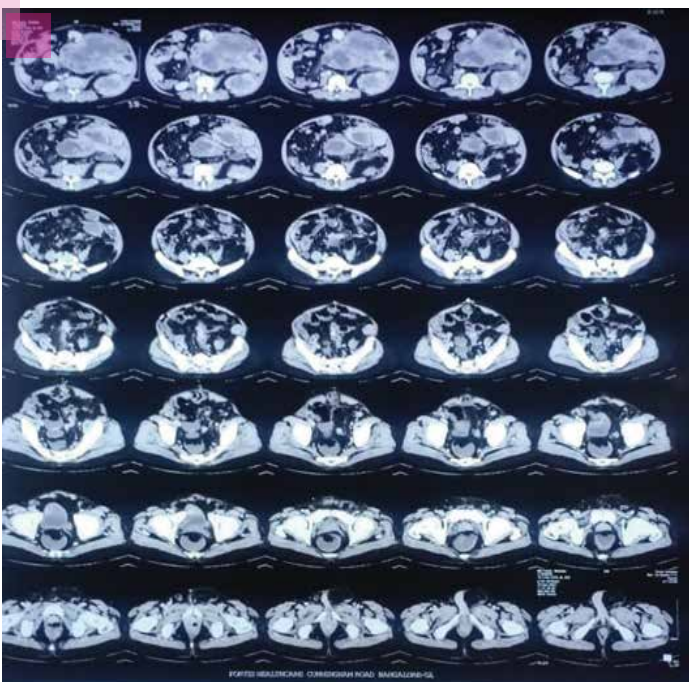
CT Scan showing the tumour
